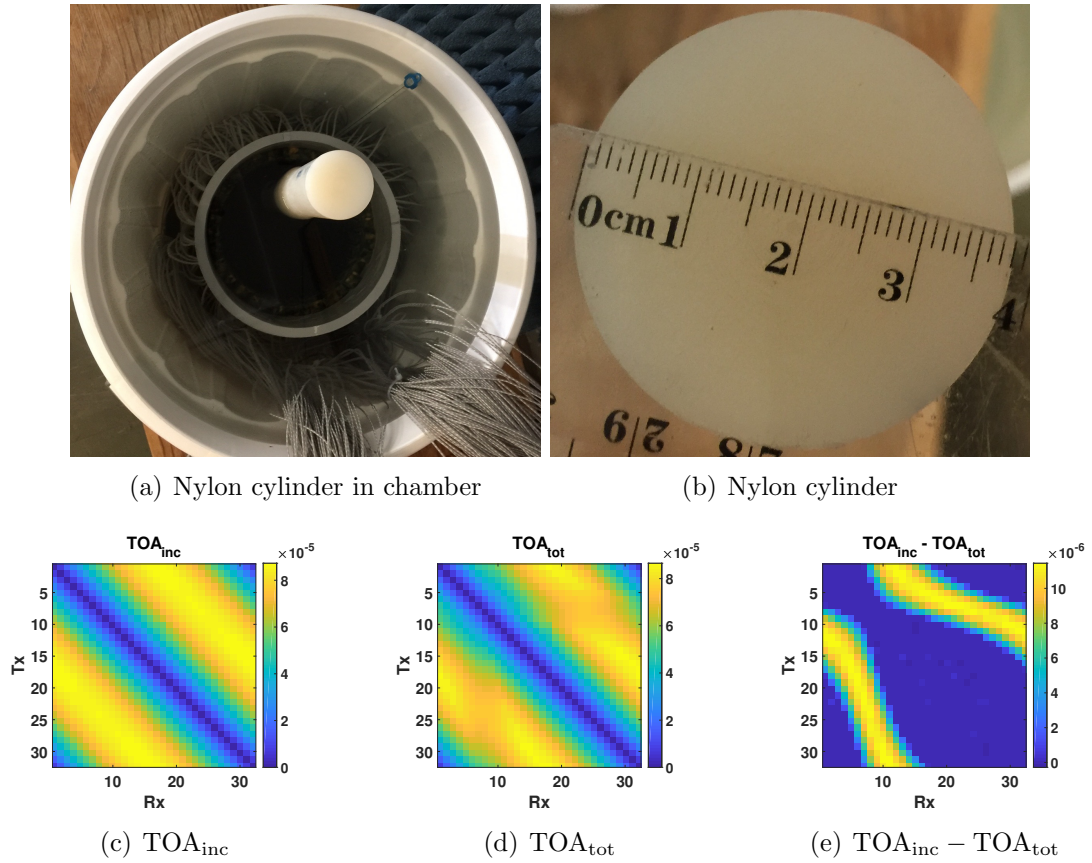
Experimental measurement of the Nylon cylinder using the ultrasound system at the University of Manitoba. The first row corresponds to the experimental set up for measuring the Nylon cylinder. The second row corresponds to the time of arrival for the incident, total and their subtraction.
